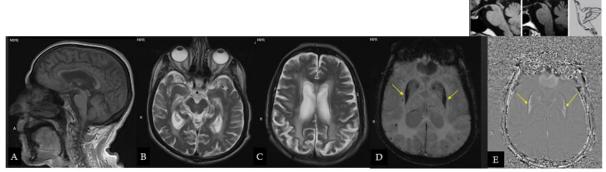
Cerebral MRI of an 83-year-old patient with a clinical diagnosis of PSP. On the sagittal T1 sequences (A), we note a decrease in the anteroposterior diameter of the midbrain, producing the hummingbird appearance with a concave aspect of its posterolateral edge. Bilateral widening of fronto-parietal sulcus on axial T2 sequences (B, C). the susceptibility sequence (SWI) (D) shows bipallidal hypo intensity contrasting with a high signal intensity on the phase contrast sequence (PHA) (E) (arrows) related to iron deposition.
